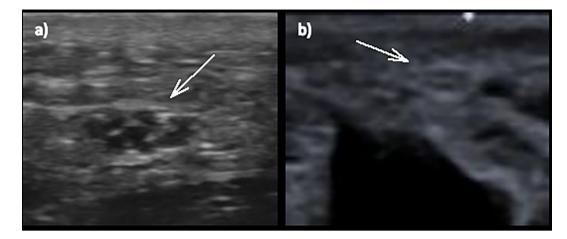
Digital median branch: (a) VHRUS (70 MHz); (b) Conventional (18 MHz) nerve ultrasound. VHRUS: very high-resolution ultrasound.
